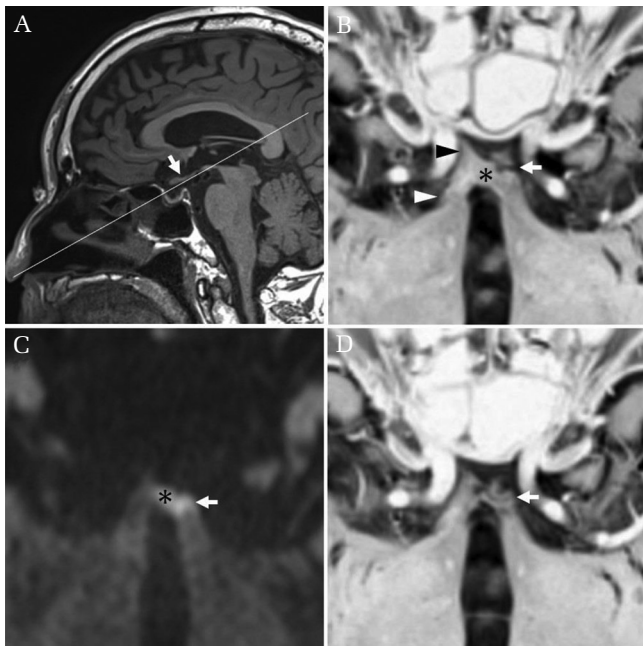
The optic nerve, optic chiasma, and optic tract were assessed by magnetic resonance imaging (MRI). (A) MRI was performed such that 2-mm slices parallel to the optic chiasma were obtained (arrow). (B) At the level of the optic chiasma (asterisk), heavily  $T_2$ -weighted MRI shows separation of the left optic nerve just distal to the optic chiasma (arrow). The right optic nerve and right optic tract are indicated by black and white arrowheads, respectively. (C) At the same level, a diffusion-weighted image shows nerve injury from the left side of the optic chiasma (asterisk) to the left optic tract (arrow). (D) At 3 months after the injury, heavily  $T_2$ -weighted MRI shows degenerative regression in the left side of the optic chiasma and the optic tract (arrow).
